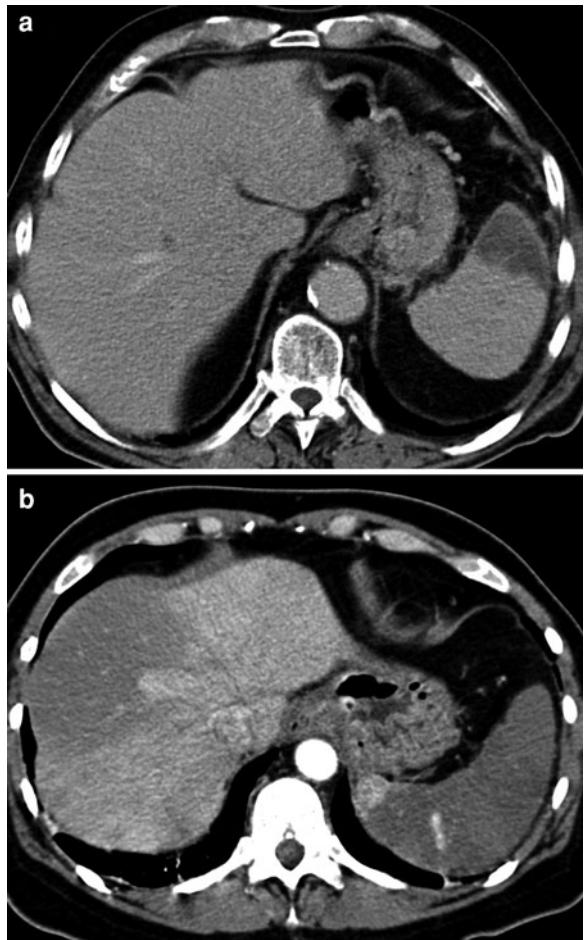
Splenic infarction in two different patients. a Axial contrast-enhanced CT scan showing peripheral wedge-shaped hypoattenuating lesions secondary to emboli. Note the peripheral hyperdense rim. b Axial contrast-enhanced CT scan showing subtotal nonenhancement of the spleen due to thrombosis of the splenic artery
